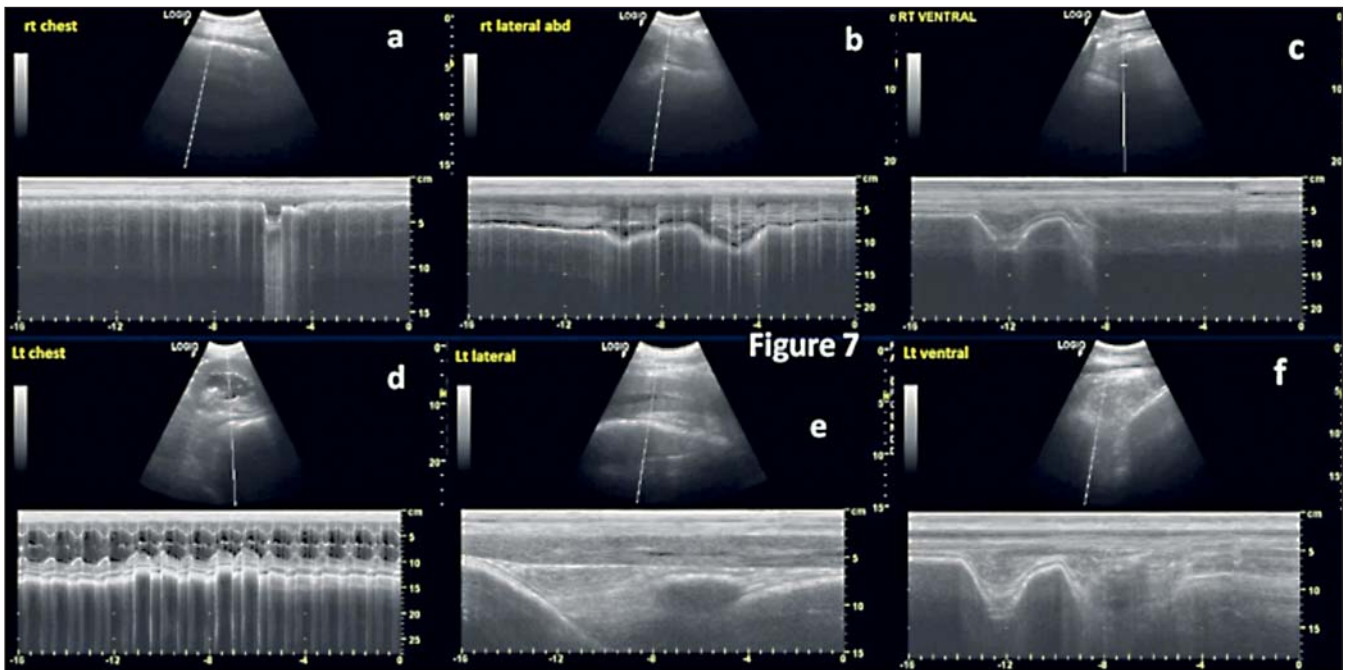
Ultrasonogram showing various type of reticular motility from various windows on the right {monophasic (a), biphasic (b and c)} and left side {monophasic with heart beat (d), folding (e), biphasic (f)}.
